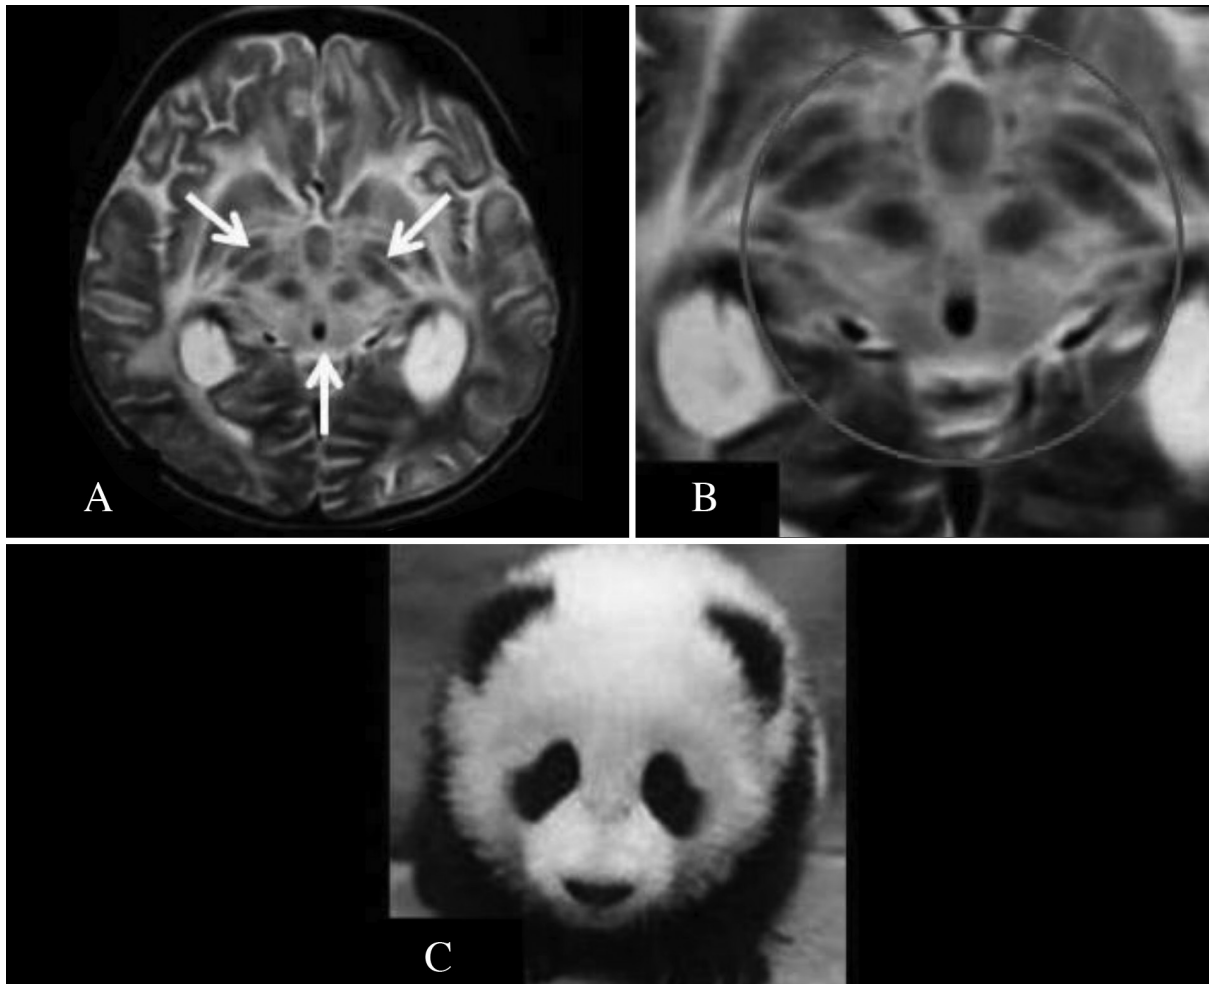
(A) Axial T2-weighted magnetic resonance image shows hyperintensity of the midbrain. It is also shown that the hypointensity of the red nucleus, superior colliculus, part of the pars reticularis of the substantia nigra, and the aqueductus were relatively spared (white arrows). (B) The magnified image of the image in (A) (red circle). (C) A photograph of a giant panda
